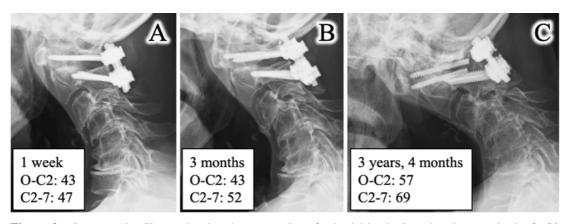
Postoperative X-rays showing the progression of subaxial kyphosis and an increase in the O–C2 angle. C1 screw breakage was recognized at 3 years and 4 months after the first operation. O–C2, occipitoaxial angle; C2–C7, C2–C7 angle
